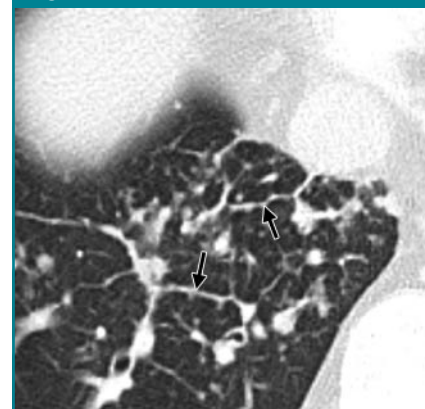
Transverse CT scan shows beaded septum sign (arrows).
